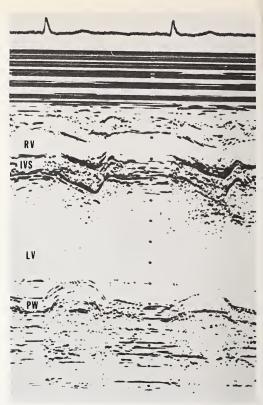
M-mode echocardiogram with the view taken at the level of aortic root (left) and left ventricle below the mitral valve (right). Note that the left atrium is enlarged and is free of echoes. The left ventricle is dilated and reveals hyperdynamic motion.
